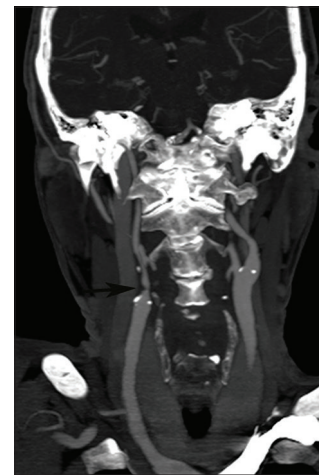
A 61-year-old man with carotid stenosis. Coronal multiplanar reformation computed tomography angiogram image in an elderly patient with pulsatile tinnitus shows moderate to severe narrowing of the right internal carotid artery at its origin (arrow).
